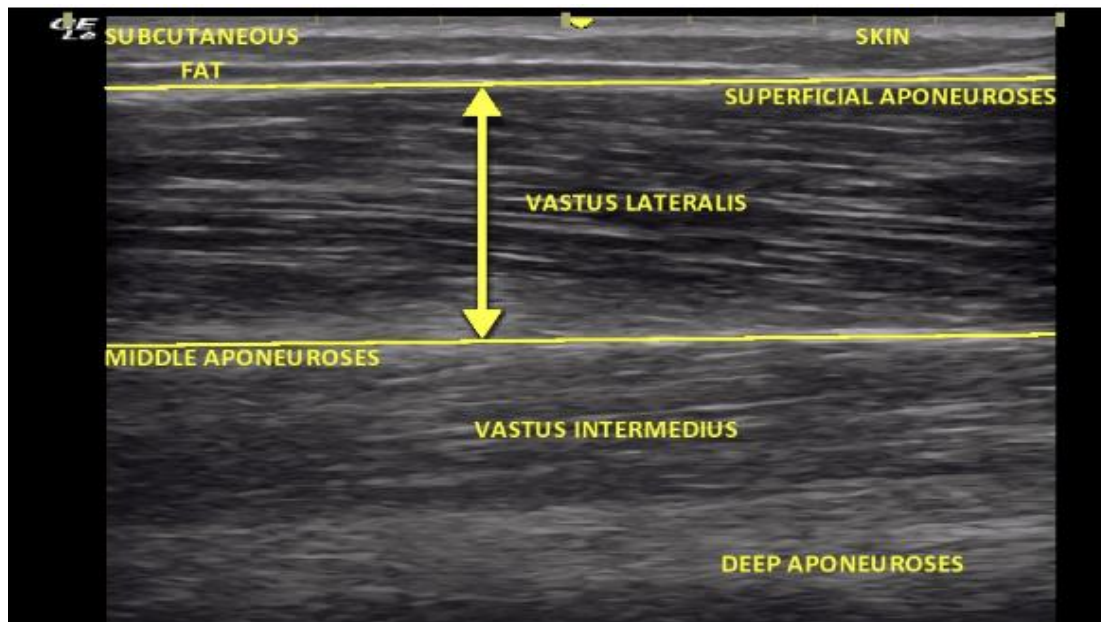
Picture showing an ultrasound measurement of the vastus lateralis from pre to post
